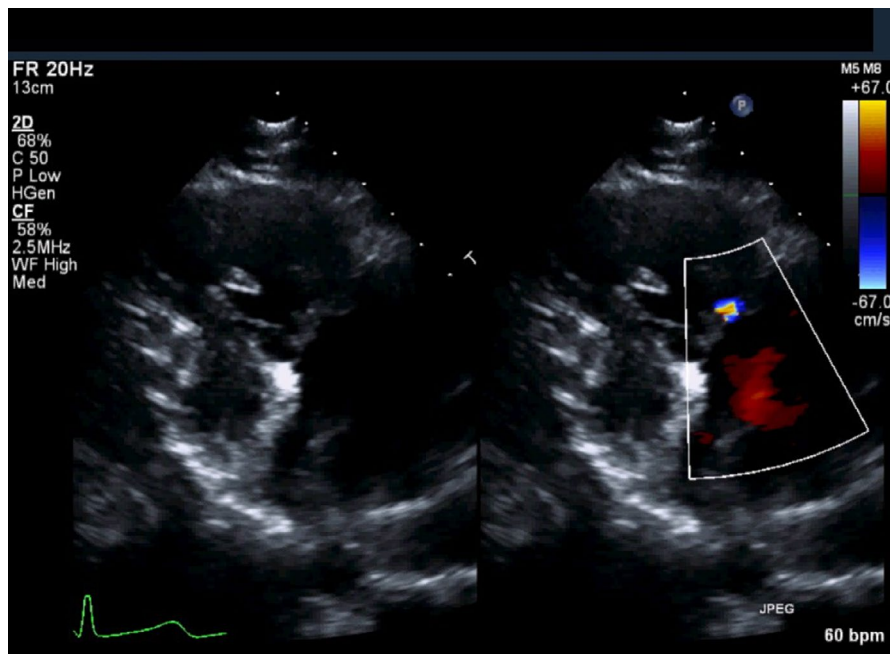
Parasternal long-axis image with posterior angulation 3 months after trauma showing tricuspid valve with physiologic regurgitation
